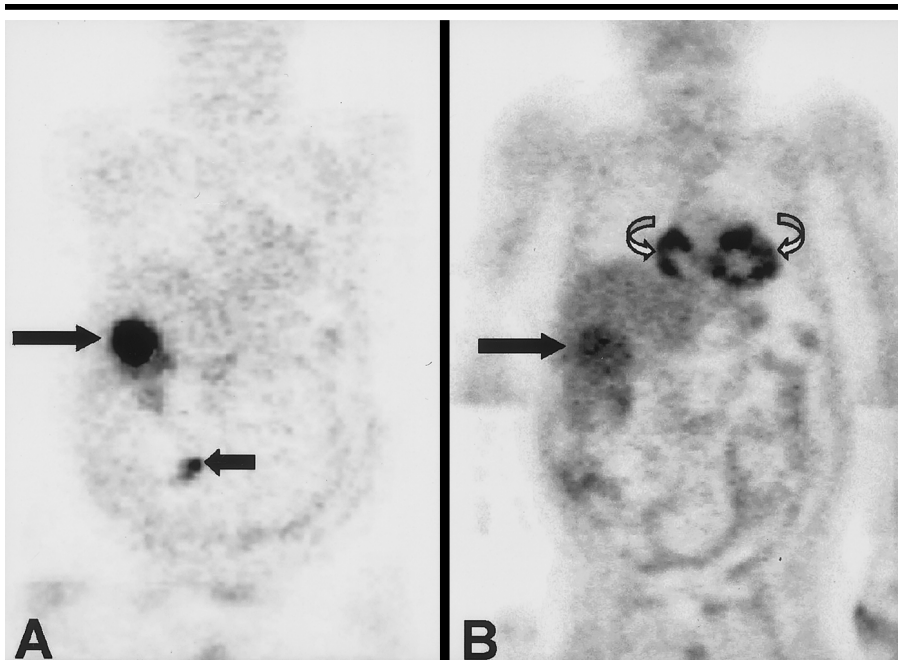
Known hepatic metastasis of a neuroendocrine tumor in a 62-year-old man. Coronal ^{18}F dopa PET image (A) clearly shows the small primary tumor (short arrow) in a loop of the ileum, in addition to the known hepatic metastasis (long arrow). Coronal FDG PET image (B) does not depict the primary tumor, and even the hepatic metastasis (straight arrow) shows only a slightly elevated glucose metabolism. Despite a 12-hour fast, pronounced FDG accumulation is found as a normal variant in the myocardium of the right and left ventricles (curved arrows).
